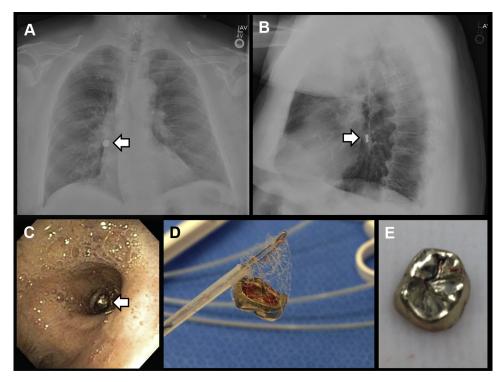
Following a dental procedure, a radio-opaque foreign body was seen on both posterior-anterior (A) and lateral (B) chest radiographs (arrows). Bronchoscopy confirmed the presence of a foreign body (C) in the bronchus intermedius (arrow), which was successfully retrieved using a basket net retrieval device (D). This recovered dental crown (E) was later reimplanted
